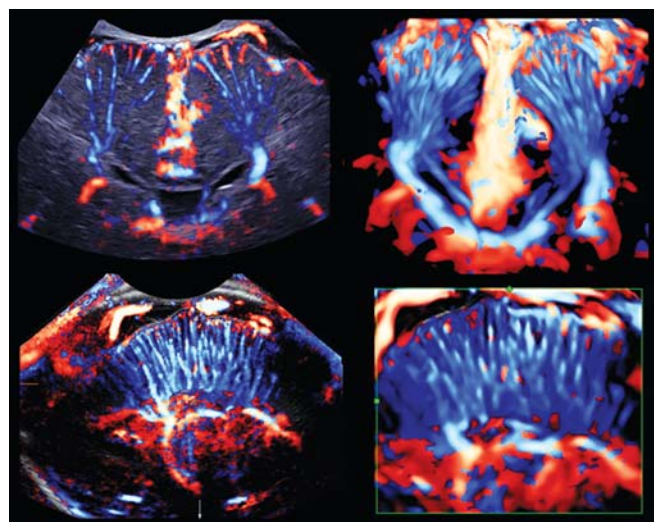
Medullary vessels in normal 29-week fetus by 3D bidirectional power Doppler. (Upper) Coronal cutting section of 2D (left) and 3D reconstructed images (right). (Lower) parasagittal cutting section of 2D (left) and 3D reconstructed images (right). Medullary veins are demonstrated between pia mater and longitudinal vein of Schlesinger in the anterior coronal cutting section and between brain surface and periventricular subependymal area in the parasagittal section
